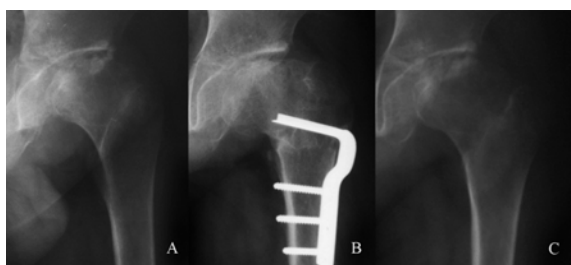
Radiographs of a hip showed gradual changed of the neck-shaft angle. (A Before surgery, B 6 weeks after PFVO, C 3 years after PFVO)
